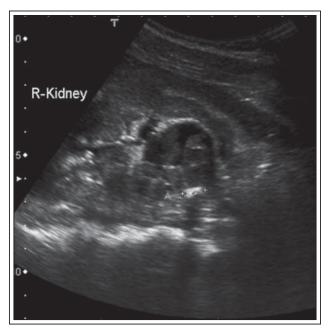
Ultrasound of the right kidney shows a heterogenous mass with a stone in the pelvis.
